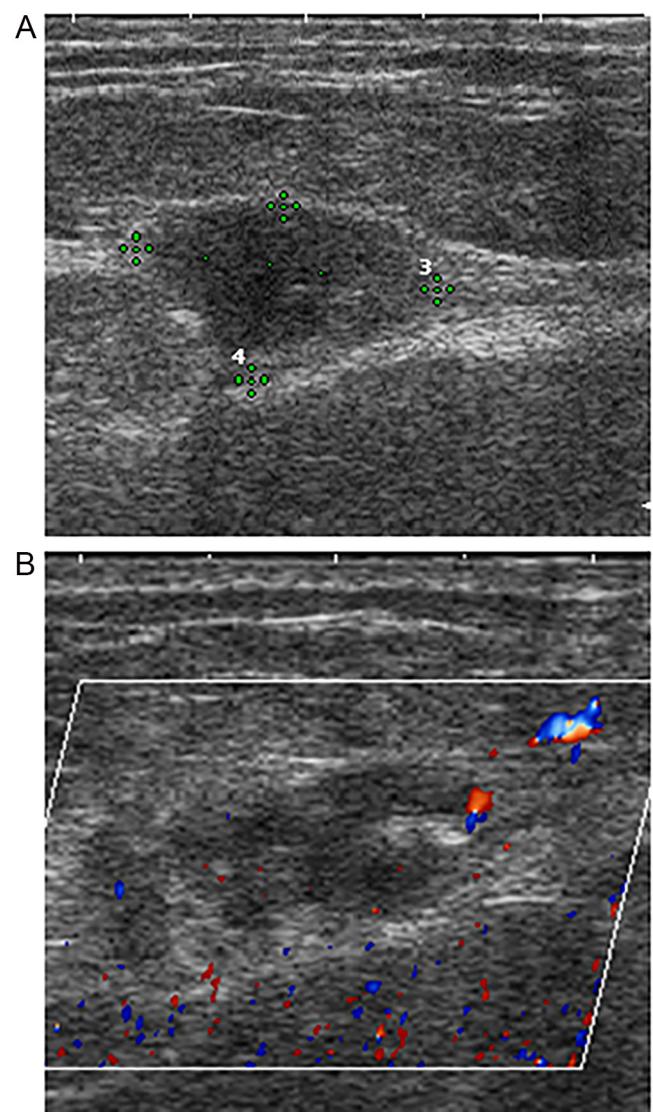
A right breast ultrasound showing a hypodense lobulated horizontally oriented lesion (A) with peripheral vascularity (B).
